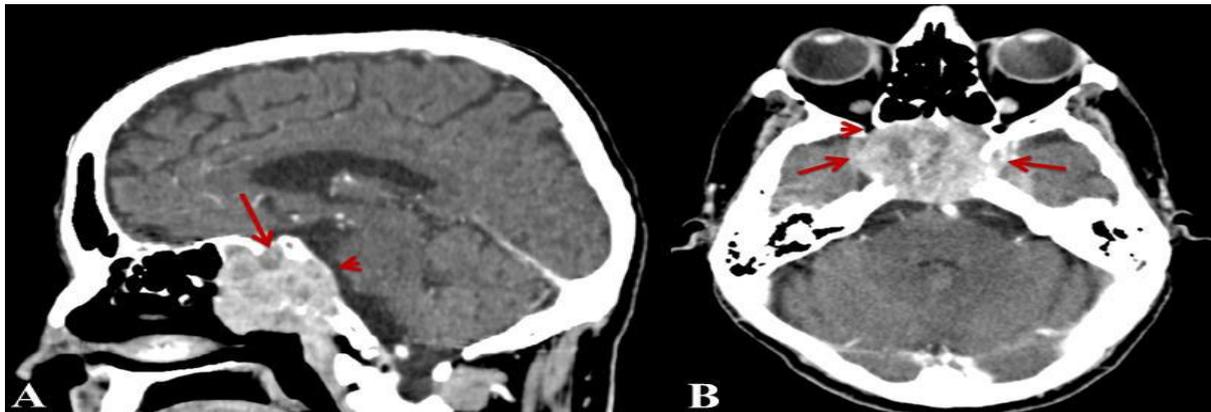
A. Head contrast-enhanced CT (sagittal image) where sella turcica (arrow) and clivus (arrowhead) are observed; B. Axial contrast-enhanced CT image where the right orbital apex invasion (arrowhead) and bilateral cavernous sinus invasion (arrows) are observed (Turliuc *et al.*,2016c).
